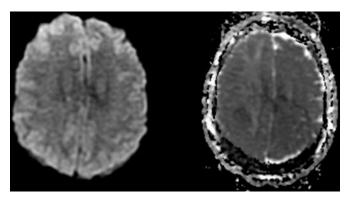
DWI and ADC map on post-op Day 2 showing no evidence of infarction or ischemia.
